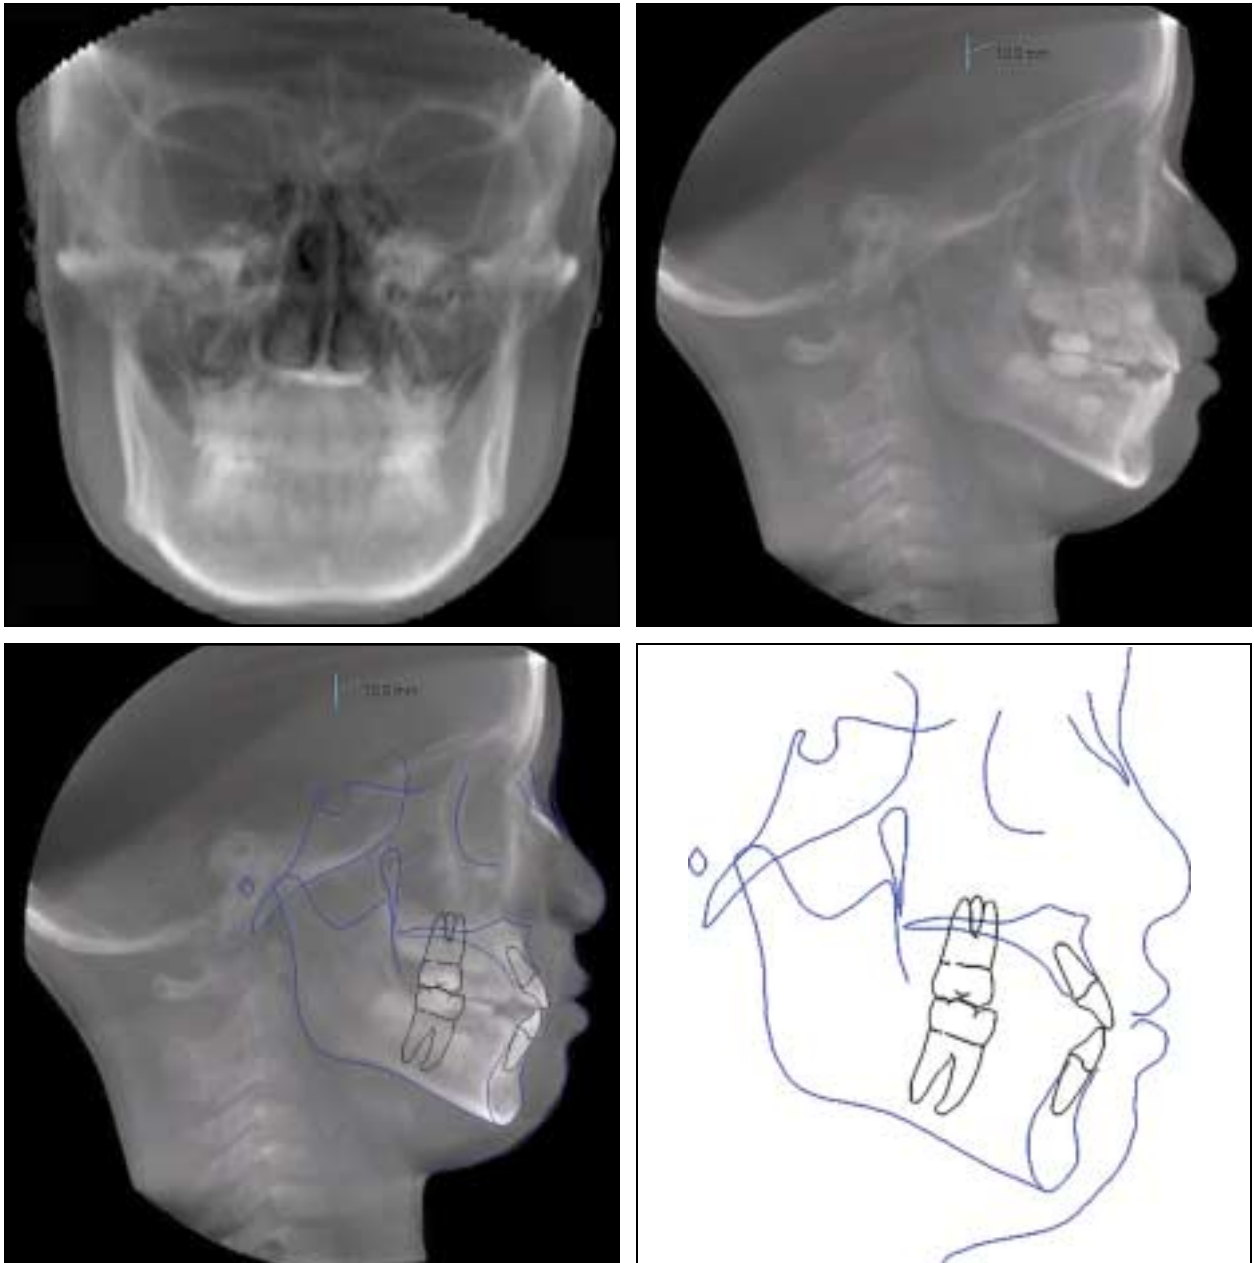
Cone Beam Computed Tomography (CBCT) frontal and lateral cephalometric views and tracings.
